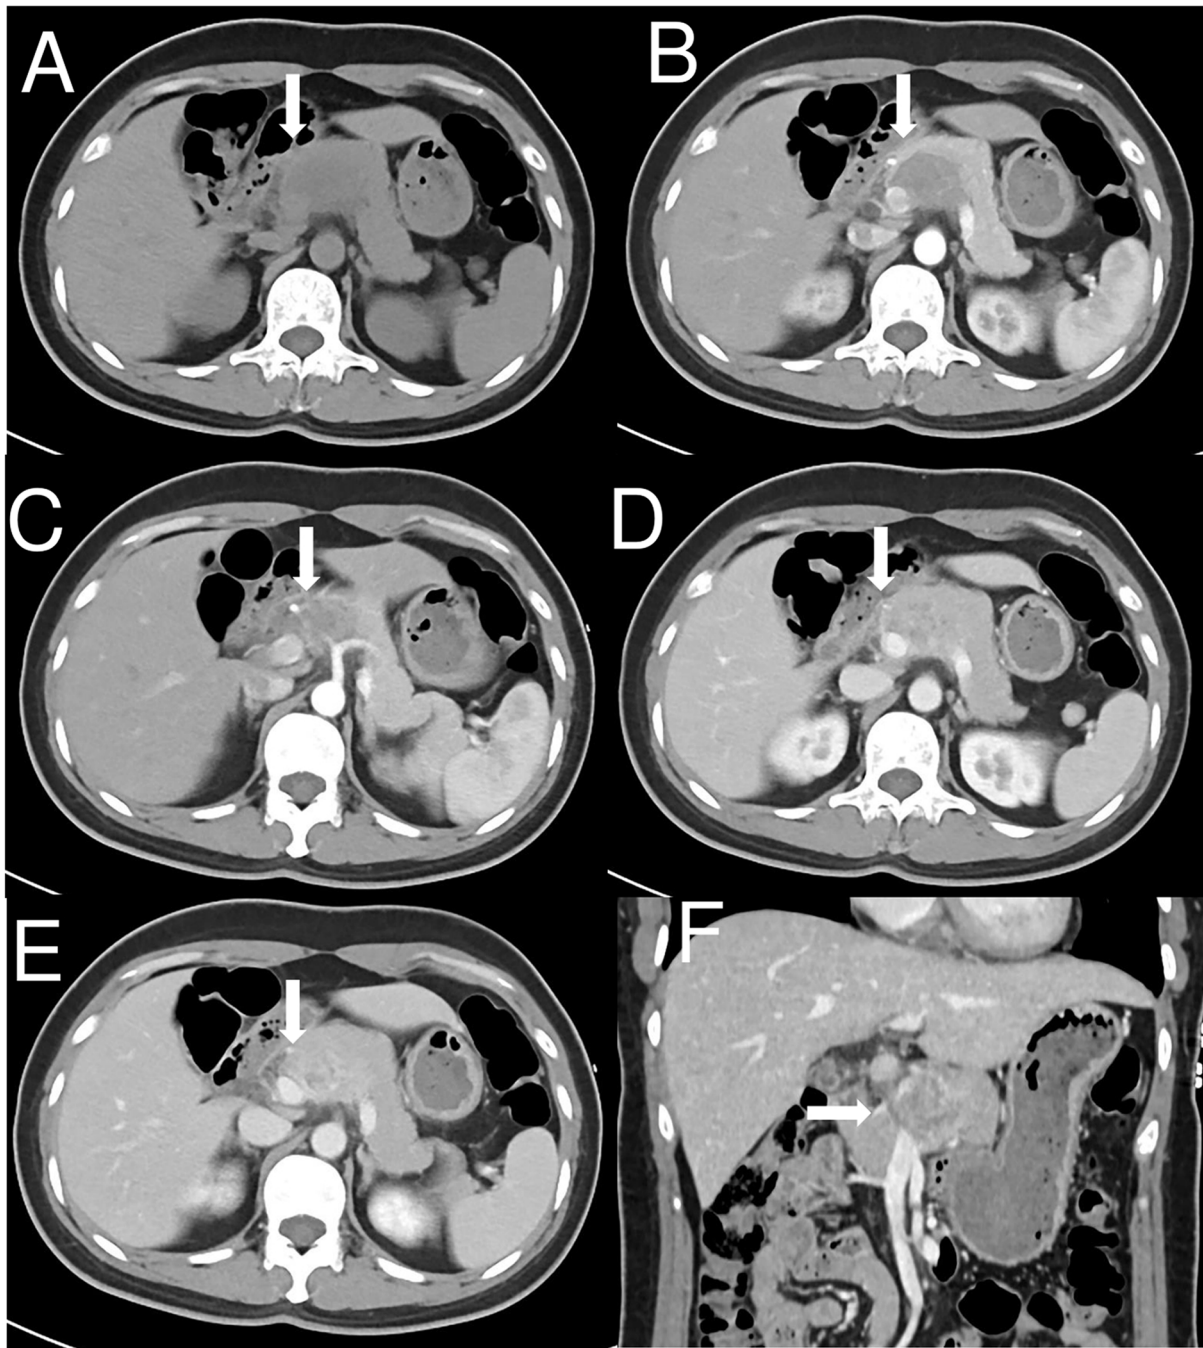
Radiological findings. (A) Unenhanced axial CT image revealing a heterogenous mass in the pancreatic head and body (arrow). (B) Arterial phase axial CT image showing slight enhancement of the lesion (arrow). (C) Arterial phase axial CT image showing the tumor invaded the common hepatic artery (arrow). (D) Venous phase axial CT image indicating further uneven enhancement of the lesion with invasion to the splenic vein (arrow). (E) Delayed phase axial CT image showing persistent enhancement of the lesion (arrow). (F) Delayed phase coronal CT image showing heterogenous enhancement of the lesion with invasion to the portal vein (arrow).
